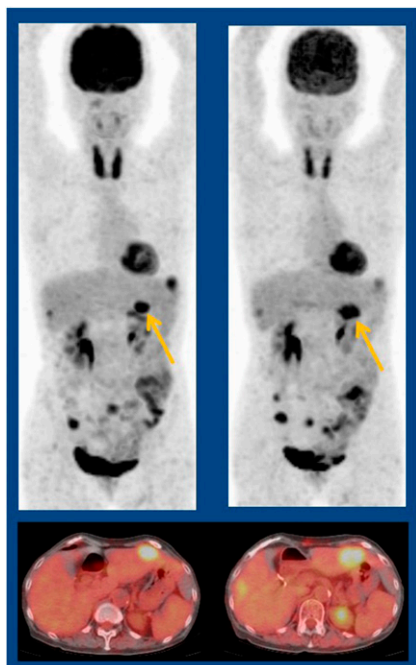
^{18}F -FDG PET volumetric parameters and texture features in prediction of response to chemotherapy in recurrent gynecologic malignancies. PET and PET/CT imaging in an example patient with ovarian cancer before treatment (left: $\text{SUV}_{\text{max}} = 6.7$; metabolic tumor volume [MTV] = 7.4; entropy = 4.3) and after 1 cycle of chemotherapy (right: $\text{SUV}_{\text{max}} = 5.5$; MTV = 15.6). Entropy (a texture feature) as assessed at baseline was predictive of nonresponse after the first chemotherapy cycle. Changes
